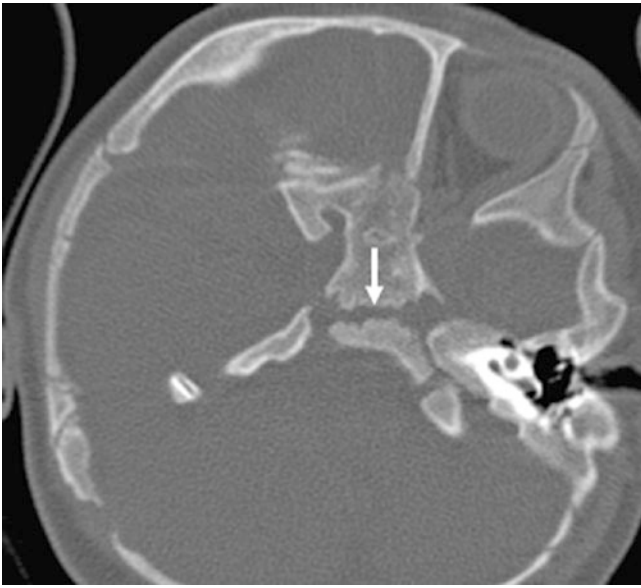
A 3 month old whose body is tilted within the CT scanner. Note an irregular SOS (*arrow*)
